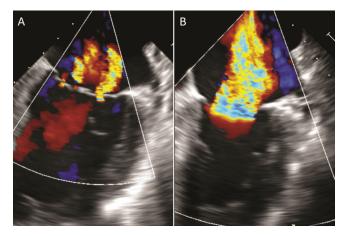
Transesophageal echocardiogram images showing (A) moderate mitral regurgitation (MR) at systolic blood pressure (SBP) of 82mmHg, which worsened to (B) severe MR at SBP of 130mmHg.
